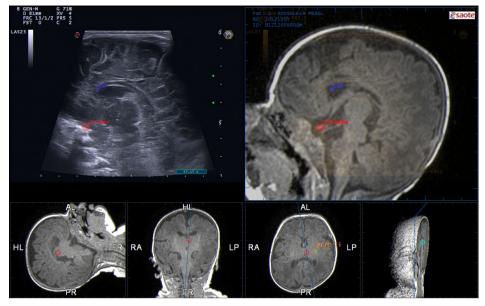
By courtesy of Esaote (Genoa, Italy). Bedside registration of CUS on MRI images.
